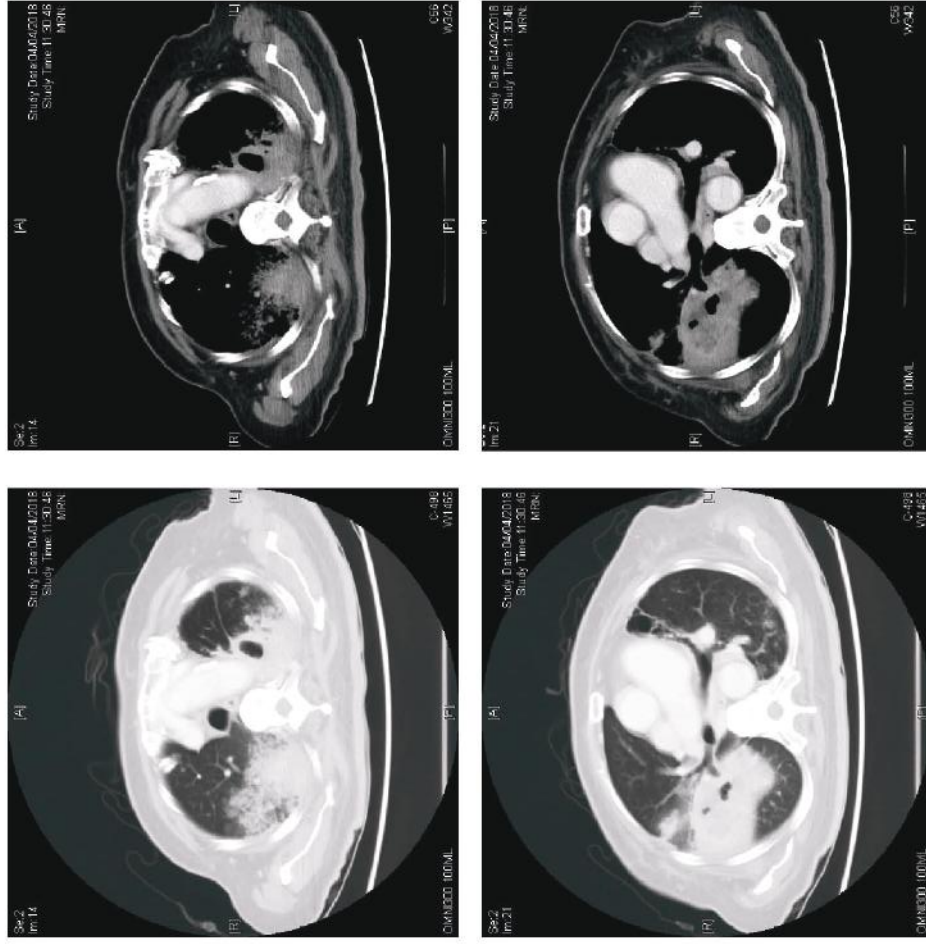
CT thorax in the third hospitalization
